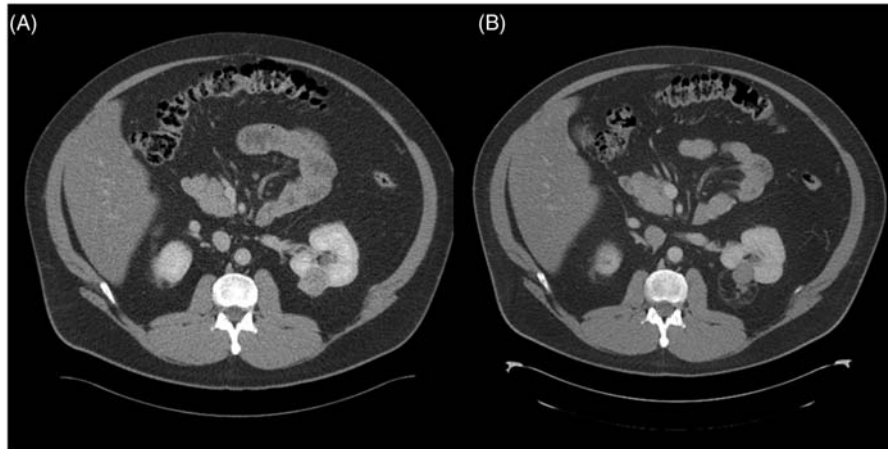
Patient with a preablation and postablation CT. (A) Preablation CT showing good enhancement of tumor. Biopsy showed this to be a clear cell renal cell carcinoma, Fuhrman Grade 2. (B) Eighteen-month postablation CT scan shows no enhancement and postoperative changes are seen surrounding the lesion. Note that even after 18 months the lesion has not shrunk completely.
